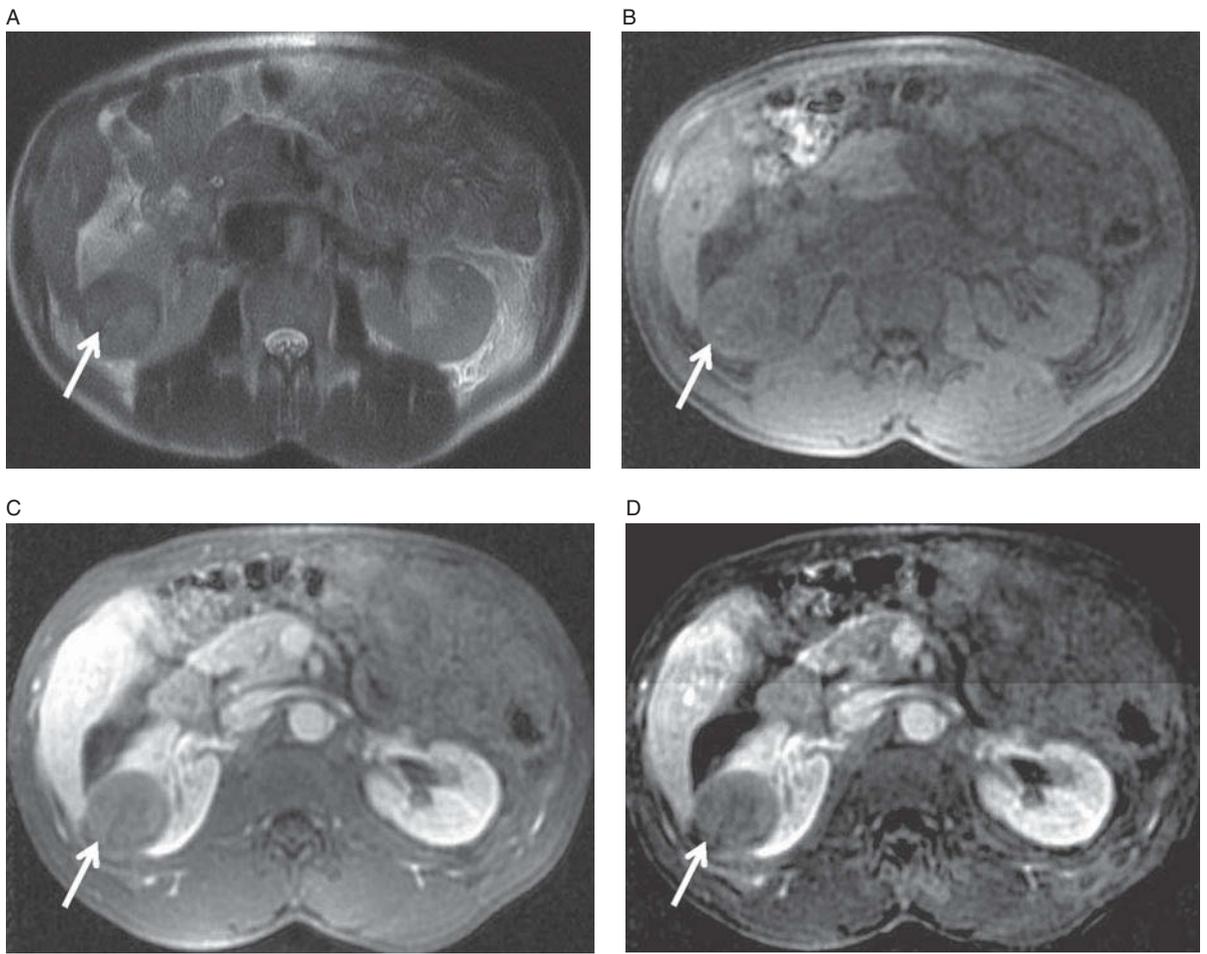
Papillary RCC (arrows). Axial T2-weighted image (A) shows a T2-dark mass in the right kidney which is dark on axial T1-weighted pre-contrast image (B) demonstrates solid, though not dramatic, enhancement on T1-weighted, fat-saturated post-contrast image (C). Subtracted image (D) shows solid, intralésional enhancement. Papillary renal cell carcinoma is frequently T2 dark.
